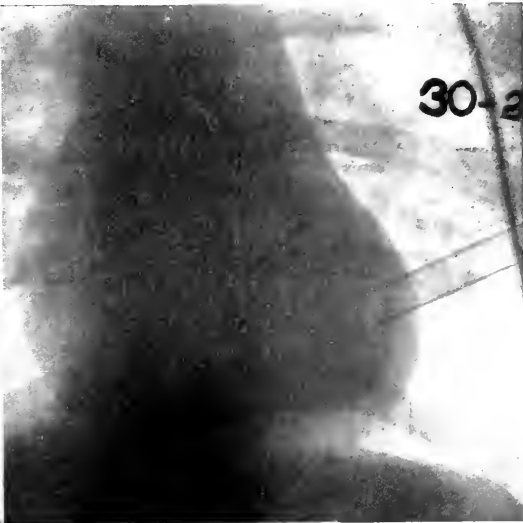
RADIOGRAPH OF SAME HEART SHOWN IN FIGURE 3 DURING HEIGHT OF SYSTOLE.
